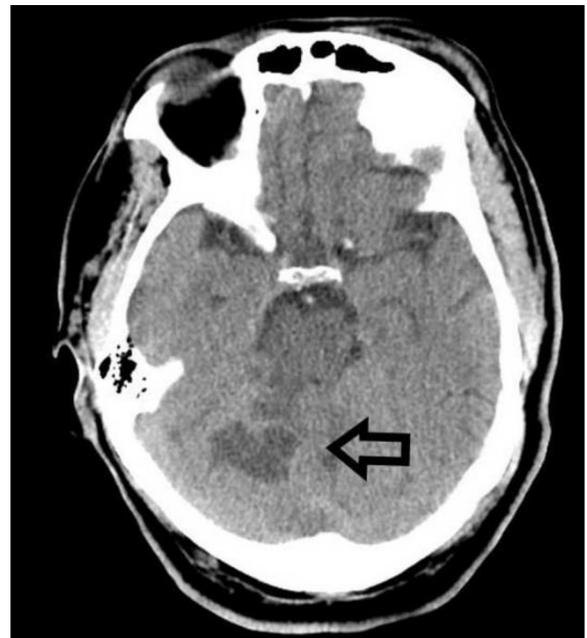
Computed tomographic image of the head with arrow pointing to multiple embolic infarcts.
